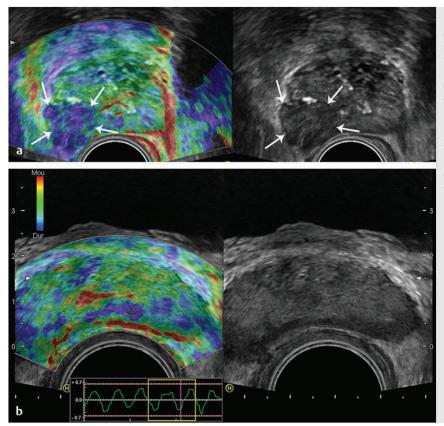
Prostate cancer pattern at strain elastography. (a) Typical hypoechogenic nodule developed in the posterior peripheral zone, with typical stiff pattern color-coded in blue (*arrows*); note that the cancer is certainly invading the capsule. (b) Diffuse prostate cancer invading the entire gland corresponding to a Gleason score 7 lesion. This diagnosis is difficult and was initially missed by the magnetic resonance imaging (MRI) study. However, the strain elastogram revealed the presence of abnormal stiff areas coded in blue distributed all over the peripheral and transition zones. This pattern was very stable with the compression–release cycles.
